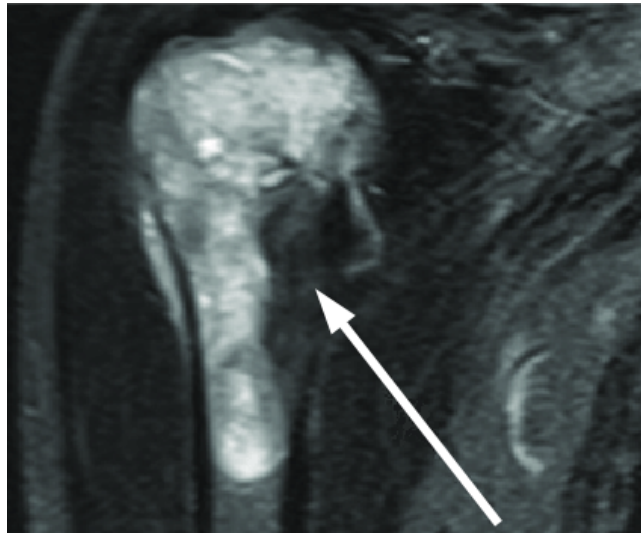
A MRI scan showing a MBD lesion located within the right proximal humerus. Image adapted from [118].
